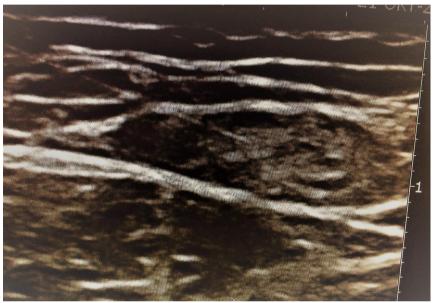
Ultrasound-guided intralymphatic injection. The needle is clearly shown from the upper left corner with its tip in the middle of a lymph node. Photo: Lars Ahlbeck
